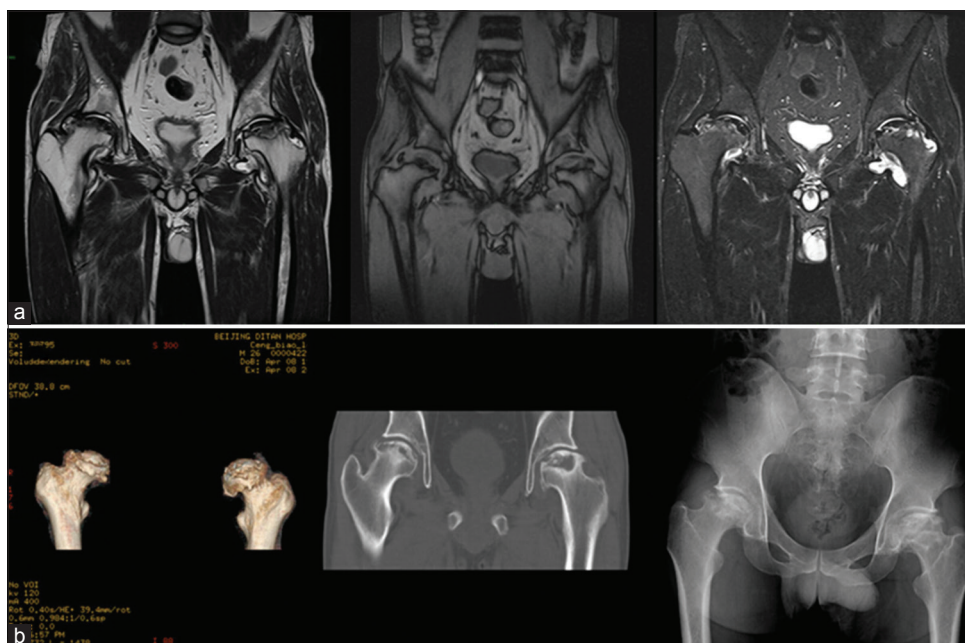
(a) Coronal magnetic resonance images demonstrate low-intensity in T1 and high-intensity edema in T2 in bilateral femur head, collapse head and rough articular surface; (b) computed tomography reconstruction shows the shape of collapse and cavitation in bilateral femur head. Plain radiograph demonstrates the collapse in bilateral femur head.
